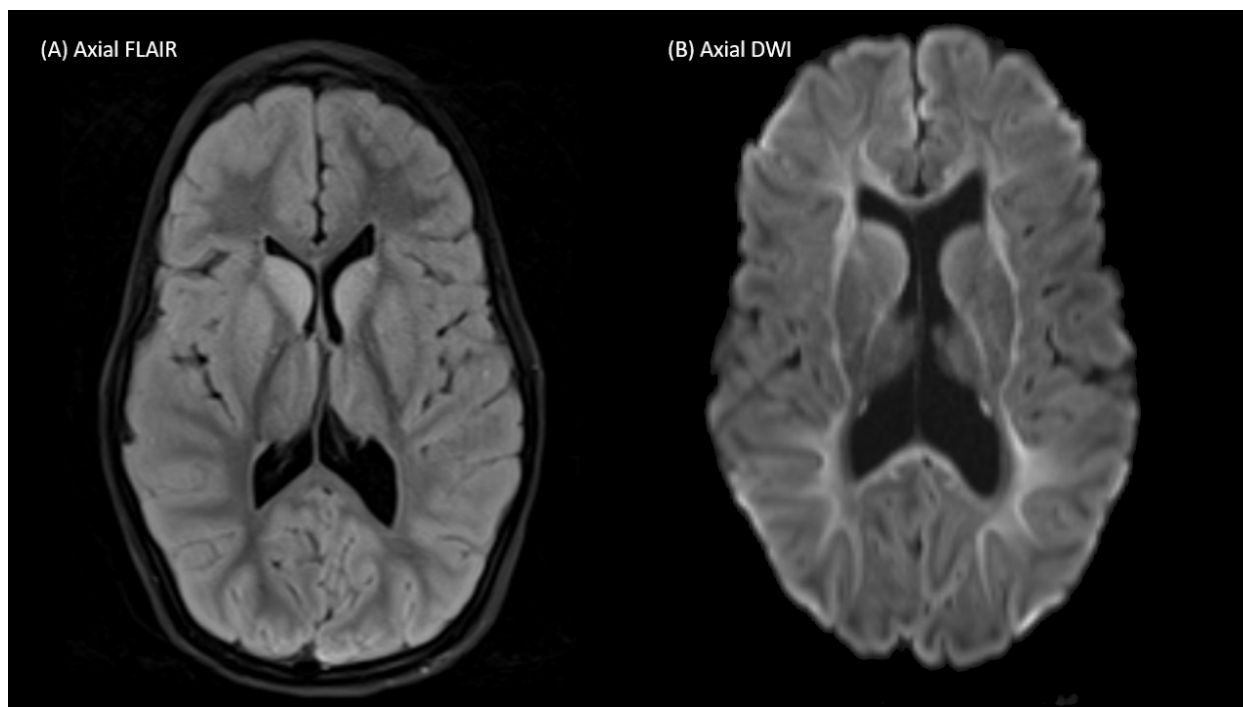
MRI brain obtained fourteen days following cardiac arrest.
